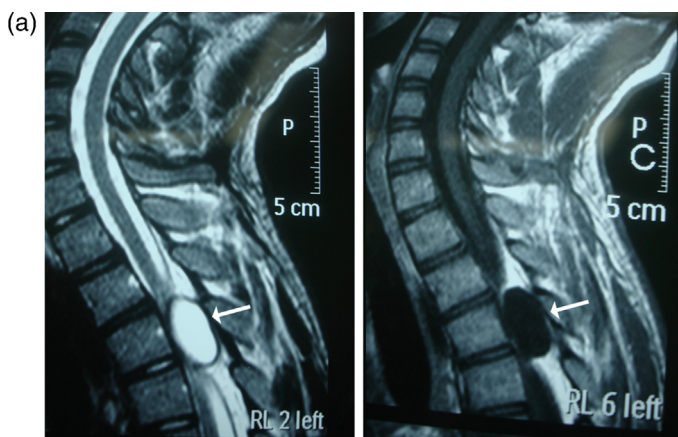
(a) The cystic lesion (white arrows) is seen as hypointense in T1-weighted and hyperintense in T2-weighted sagittal MRI at the T3 and T4 levels. (b) The cystic lesion (white arrows) is seen as hyperintense in T2-weighted axial MRI at the T3 and T4 levels.
